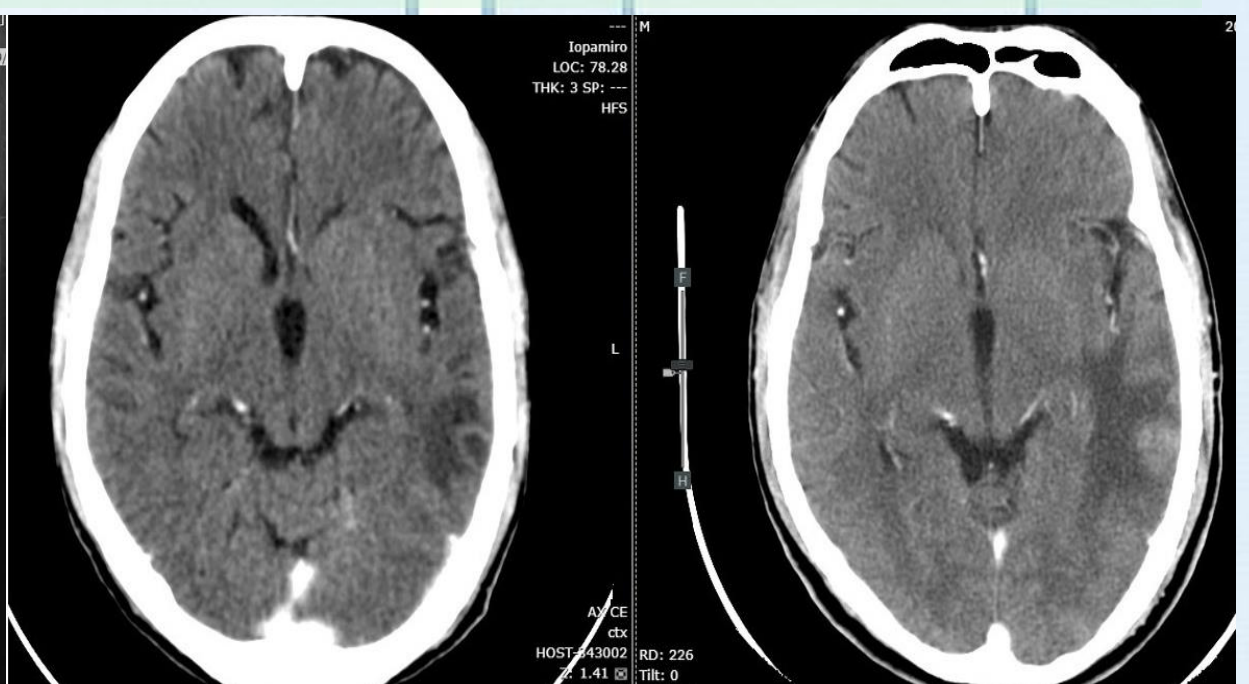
CT Brain showed ring enhancing hypodense lesion size 1.4x1.1 cm. at left temporal lobe with surrounding vasogenic brain edema and CT Brain after treatment 4 weeks showed decrease size of rim-enhancing lesion.
